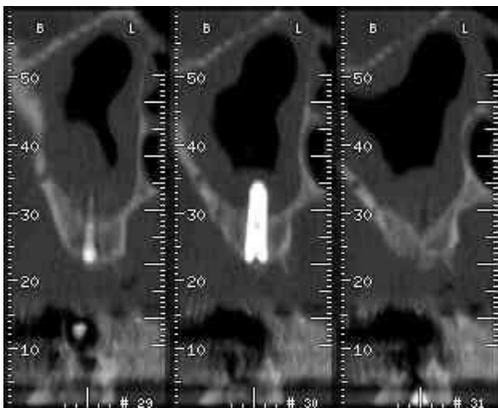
Cross-sectional view of CT scan at # 17 showing grafted CGF in the new compartment of maxillary sinus.
